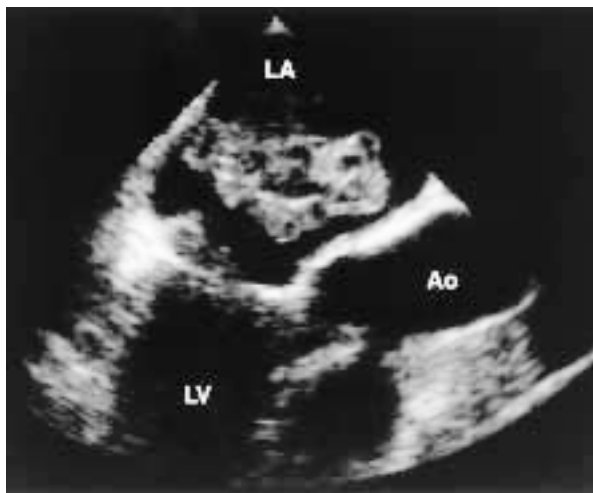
Transesophageal echocardiogram (three-chamber view)
